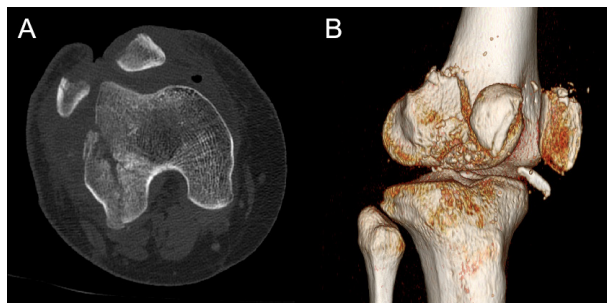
The axial CT image (A) shows a right intracondylar distal femur fracture (Arbeitsgemeinschaft für Osteosynthesefragen–Orthopaedic Trauma Association [AO/OTA] type B1) in a 23-year-old woman who was involved in a motor vehicle collision. The three-dimensional CT image of the right knee (B) shows a severely comminuted stellate fracture of the patella (AO/OTA type C3)
